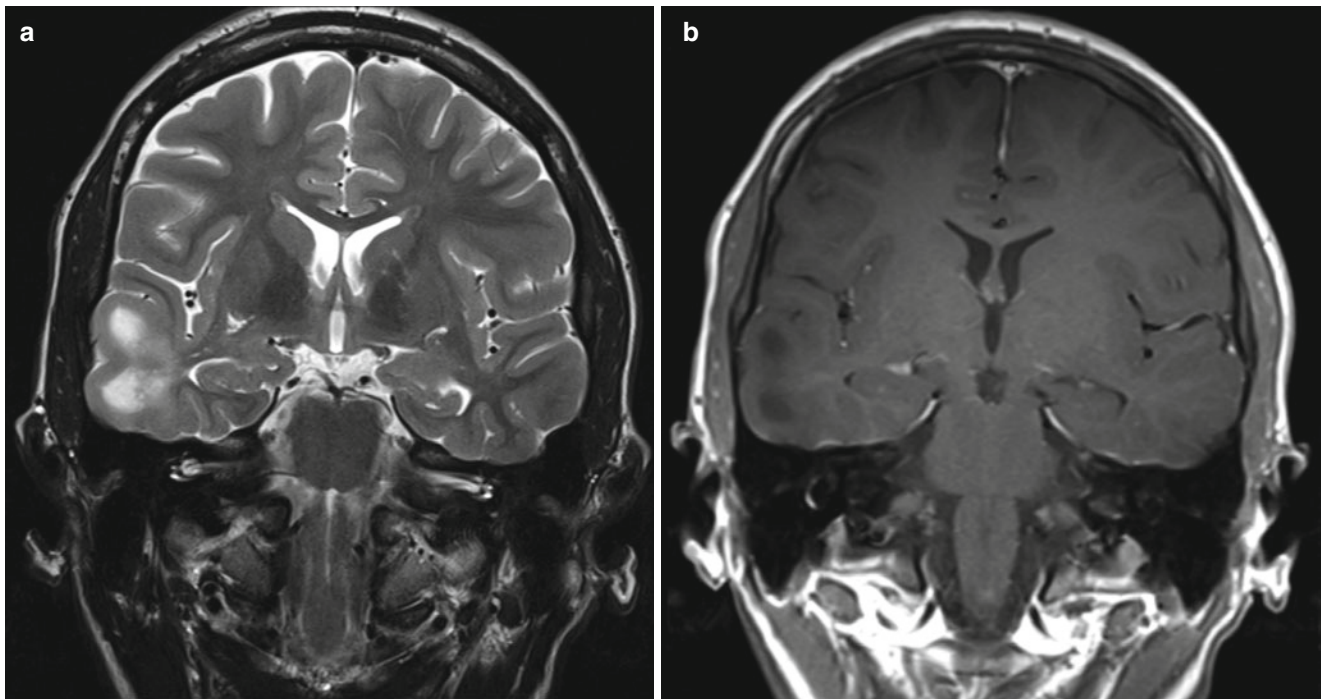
Three cases of focal cortical dysplasia type II. (a, b) patient 1; (a) coronal T2 with large subcortical area in the right temporal lobe with prolonged T2. The increased signal stretches in to the temporal horn of the right ventricle; (b) coronal T1 with gadolinium. The corresponding area has decreased signal on T1-weighted image. No enhancement. (c, d) patient 2; (c) axial T1 IR with very subtle signal changes at
